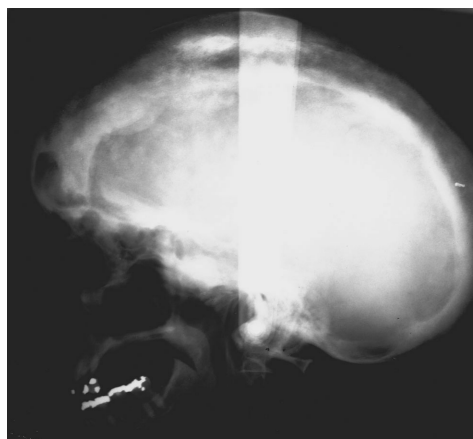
The lateral cephalometric skull radiograph shows multiple small radiopaque areas consistent with a cotton wool appearance throughout the cranial bones, and thickening of the diploë.
